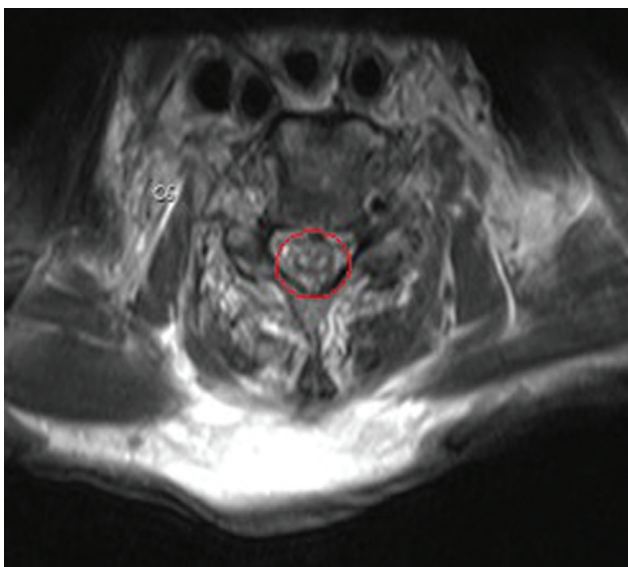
A 57-year-old man status post-BAE for massive hemoptysis with paralysis. MRI demonstrates the classic high T2 signal “owl-eye appearance” on axial T2-weighted imaging (circle) seen with infarction of the anterior spinal artery. (Image courtesy of Keith Quencer, MD.)
